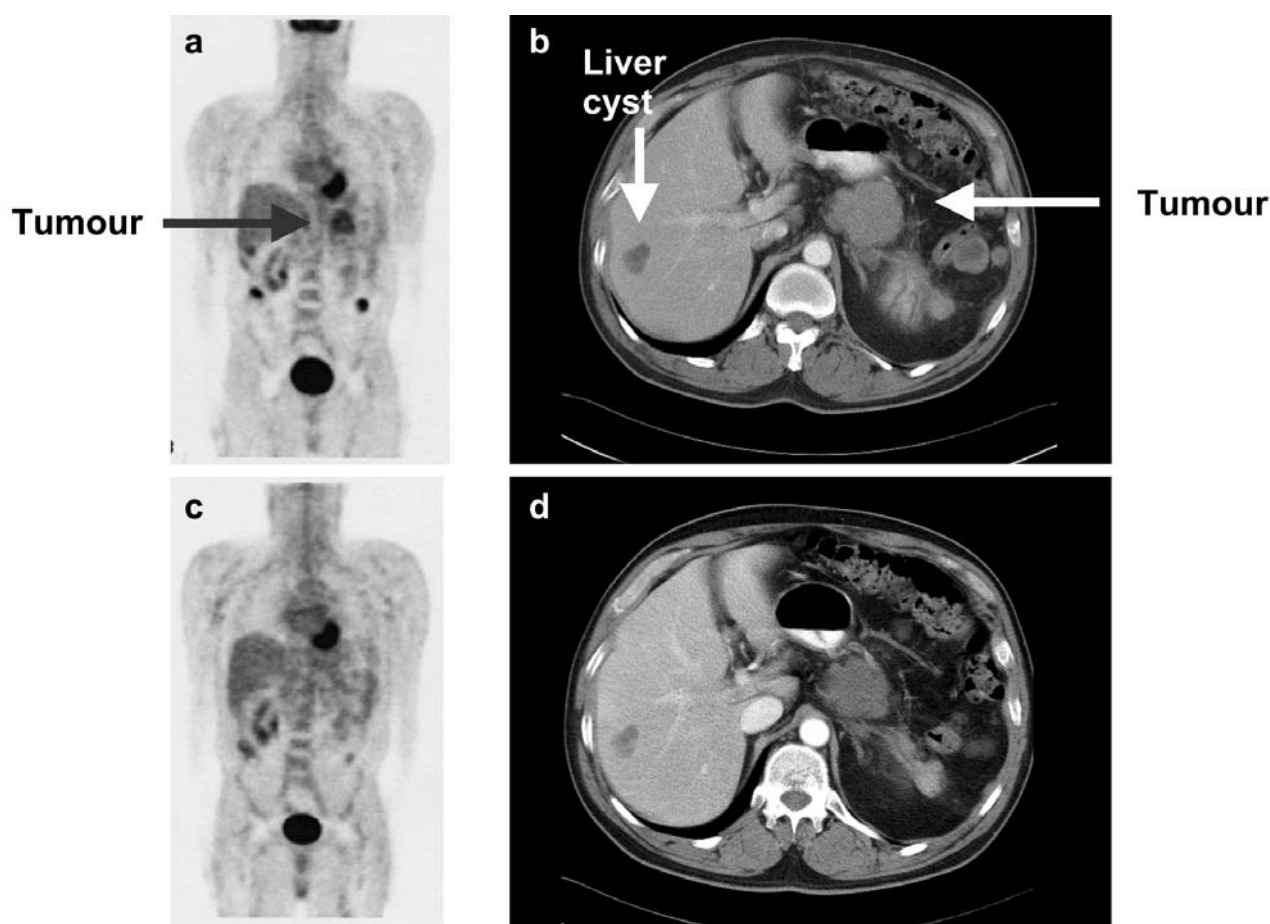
$^{18}\text{F}$ -FDG-PET and CT scans of patient #4.  $^{18}\text{F}$ -FDG-PET scans before and on day 8 of imatinib mesylate therapy (a and c, respectively) as well as CT scans before and 4 weeks after beginning the imatinib mesylate therapy (b and d, respectively). Note that on  $^{18}\text{F}$ -FDG-PET the major lesion in the left upper abdomen had completely disappeared, and only minor foci could be detected in both lower quadrants. In contrast, on the CT scan the major lesion in the upper abdomen showed only a minor shrinkage. The liver cyst shown is benign.
